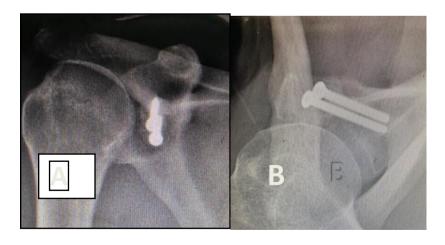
A)anteroposterior, B) axial radiographs of a shoulder with the correct position of the coracoid process.
